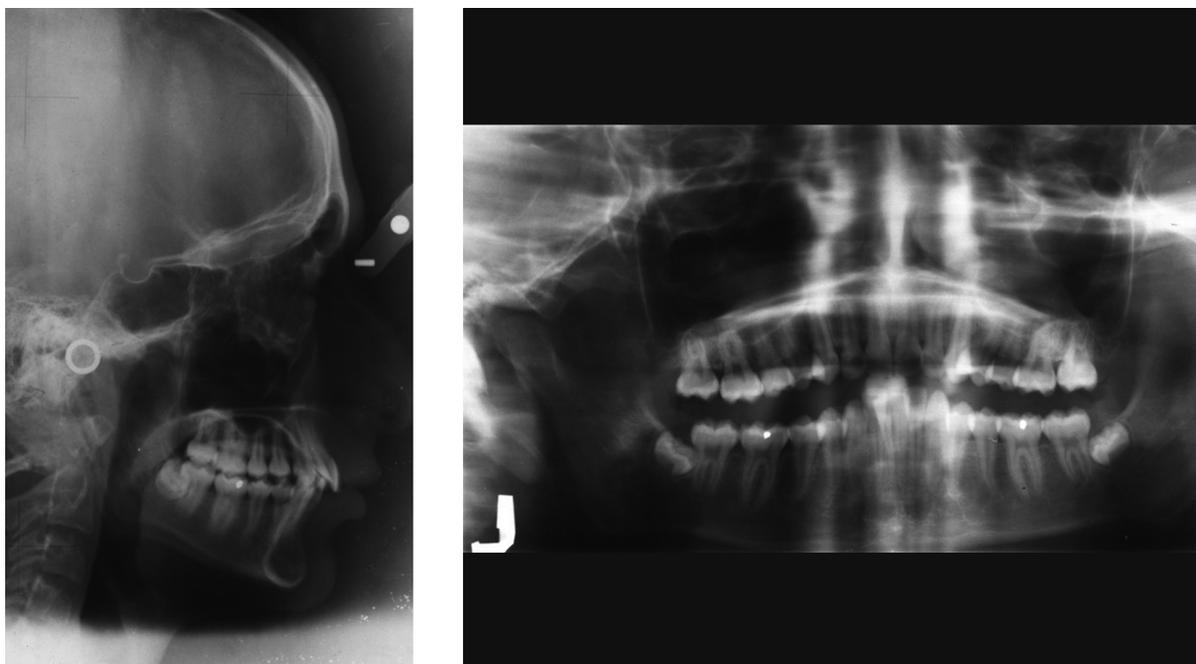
A - B, Pre-Treatment Radiographs
